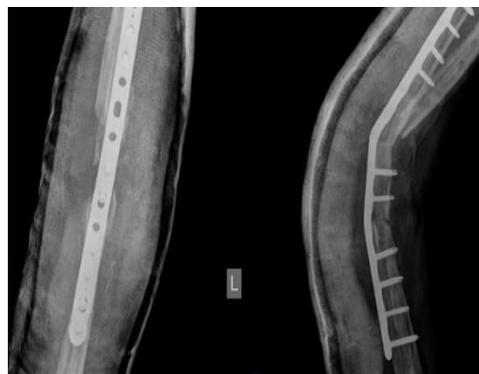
Left elbow X-ray/Post-operation (first day)
